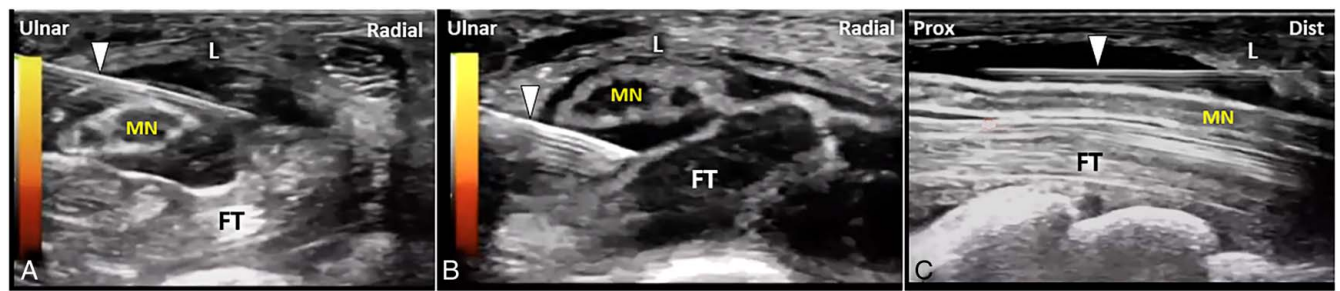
Ultrasound-guided injection approaches for CTS. Short-axis and long-axis in-plane techniques allow accurate perineural delivery of the injectate around the median nerve.
